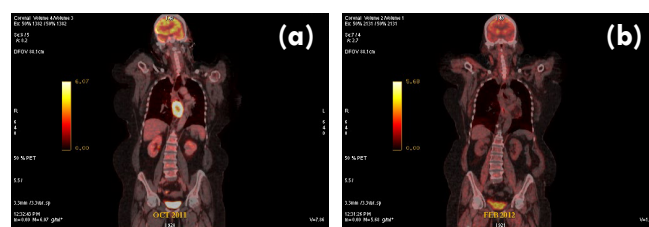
(a): Coronal fused image showing esophageal lesion with increased FDG uptake (before treatment). (b): Coronal fused image, corresponding to figure 2A showing near complete metabolic resolution with regression in wall thickening (after treatment).
